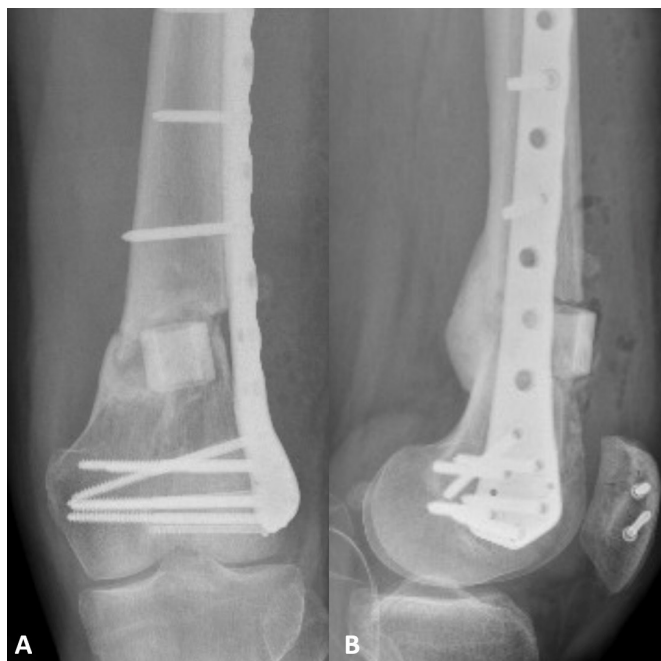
Postoperative X-rays of the left distal femur after the intervention at the site of non-union. A cylindrical synthetic graft has been placed to fill the bone gap after non-union tissue debridement. (A) Anteroposterior view. (B) Lateral view.
